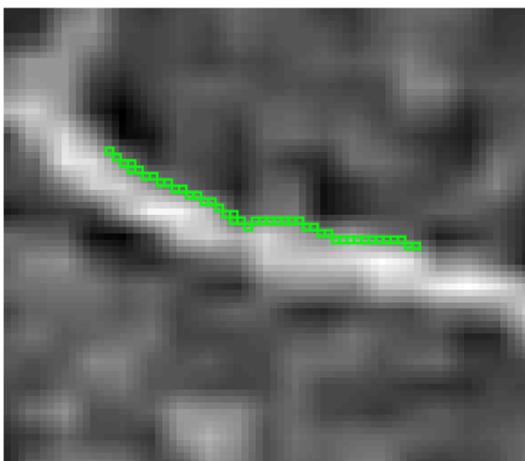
chest CT part, of an image rated as good image quality
